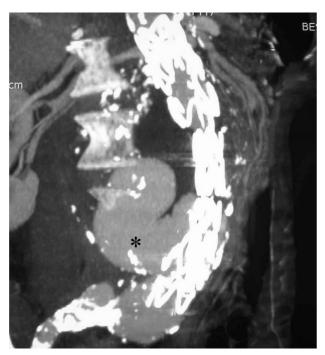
Angio-CT done three months later. Presence of a distal type I endoleak (\*); the aneurysm size increased.
